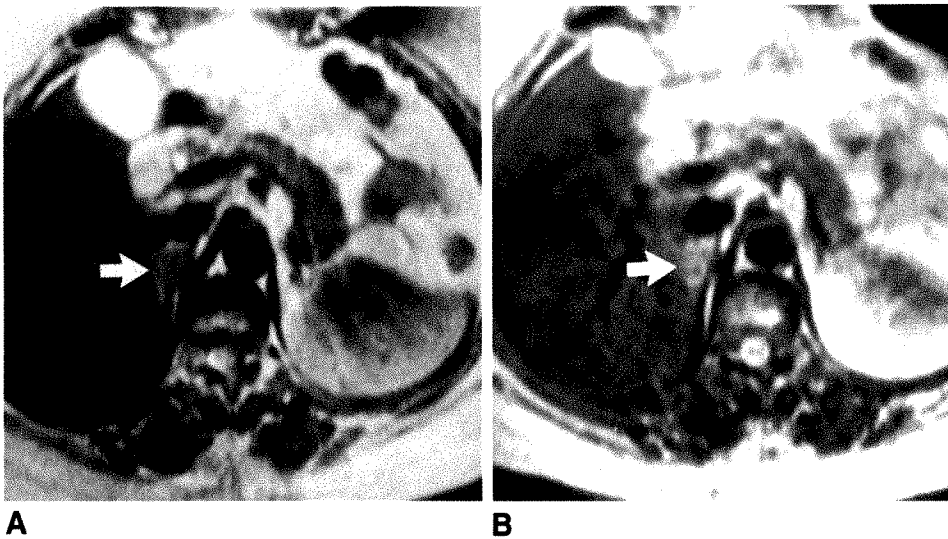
T2-weighted MR images (3000/70, 256 × 128 matrix, two excitations) of adrenal metastasis. Lesion was not present on a CT study obtained 2 months before MR.
